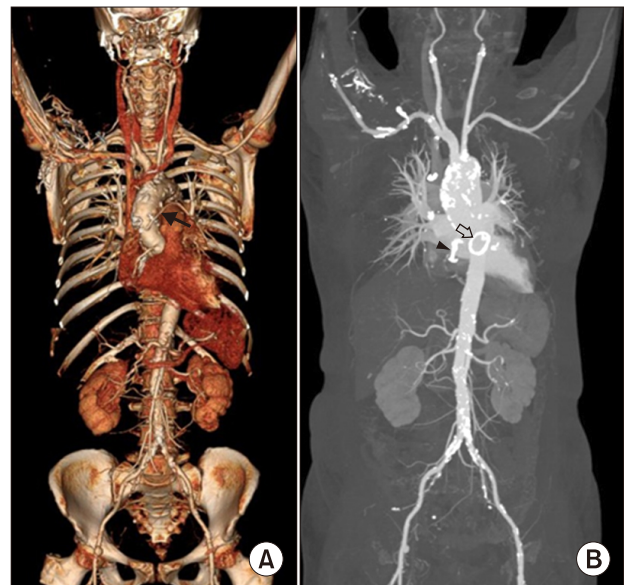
(A, B) Preoperative computed tomography demonstrating diffuse and heavy calcification of the ascending aorta, abdominal aorta, and ilio-femoral vessels (black arrow, patent aorto-coronary graft; black arrowhead, tricuspid annular ring; empty arrow, bioprosthesis mitral valve).
